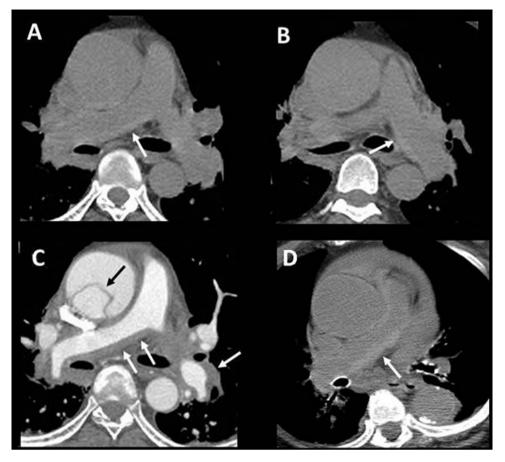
A–C 49-year-old man with chest pain (Patient 2). A conventional coronary angiogram was performed and followed by a non-enhanced (A, B) and contrast-enhanced (C) chest CT. (A, B) Linear increased attenuation is seen along the wall of the proximal pulmonary arteries (white arrows). (C) There is an intimal flap (black arrow) in the ascending aorta, and mural thickening of the pulmonary arteries (white arrows). (D) 89-year-old woman with acute type A aortic dissection (Patient 6). Non-enhanced chest CT shows increased attenuation along the wall of the right pulmonary artery (white arrow).
